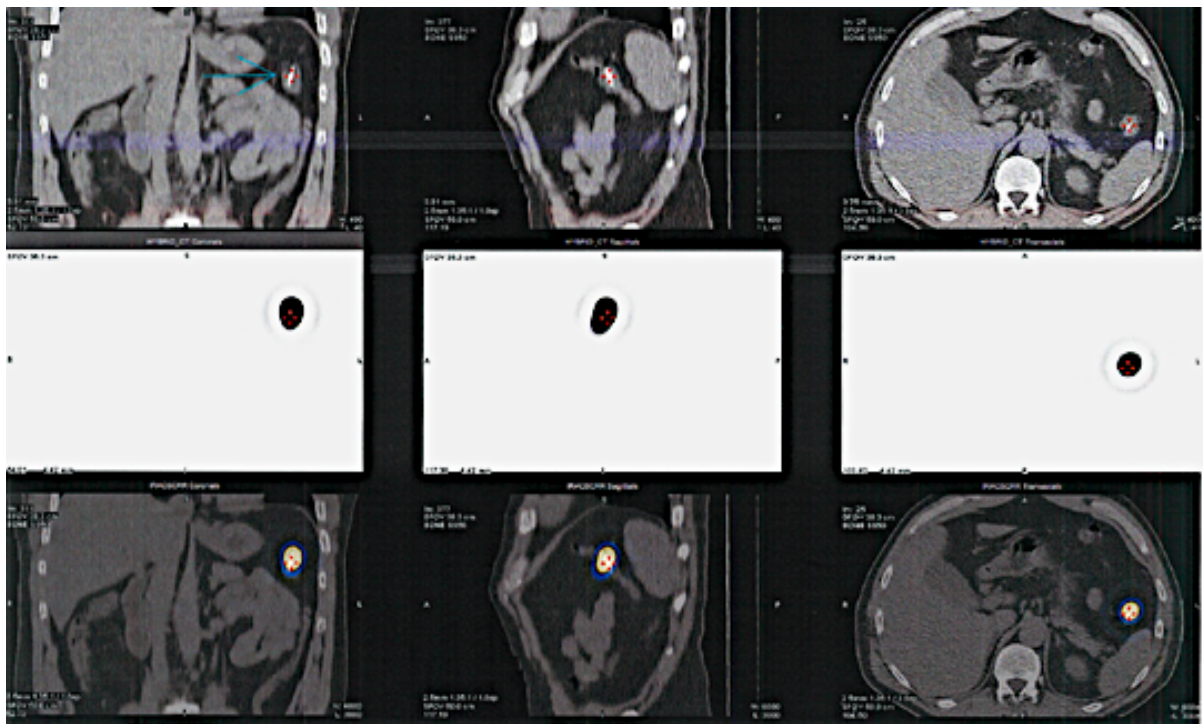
Example of coronal, sagittal and axial CT with superimposed SPECT imaging following radioisotope injection at the SF, captured at the 1-hour, 2-hour, and 4-hour time points. The blue arrow (top left) indicates the SF, identifiable by the focal uptake and the radio-dense Resolution clip.
